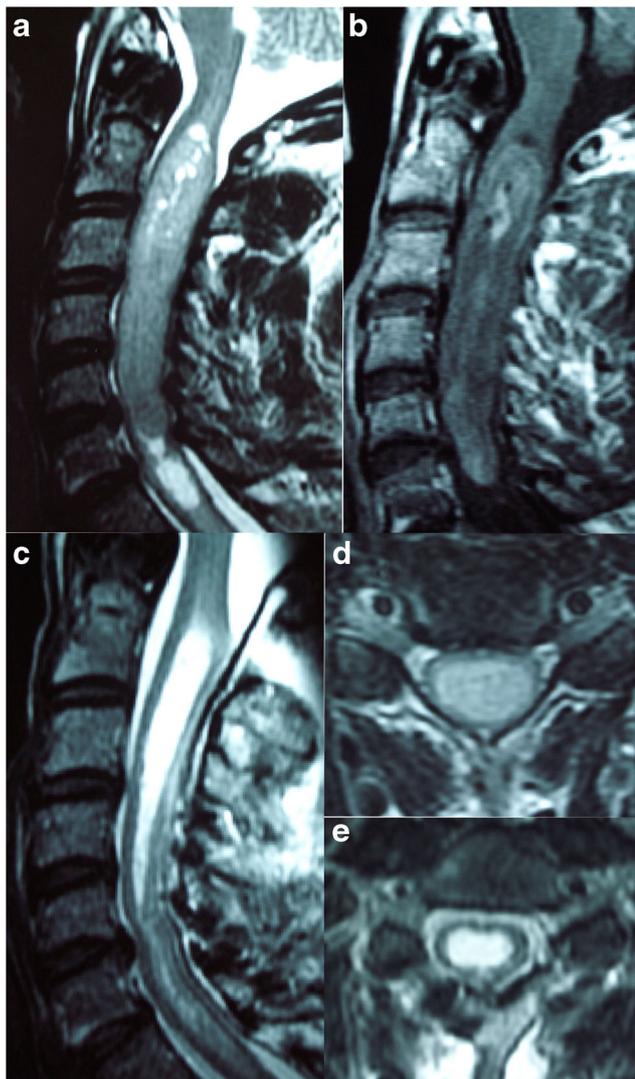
Intramedullary endypymoma WHO II, C2 to C6. The tumor was removed en bloc via a midline laminotomy approach and midline myelotomy supported by neuromonitoring (see Video 2). The tumor is bordered by a small syrinx cavity at the top and the bottom (a, T2w MRI), enhances irregularly with gadolinium (b, T1w MRI with gadolinium) and is located centrally within the spinal cord (d, T2w MRI). After resection, the spinal cord is decompressed and the resection cavity filled with CSF (c and e, Tw2 MRI)
